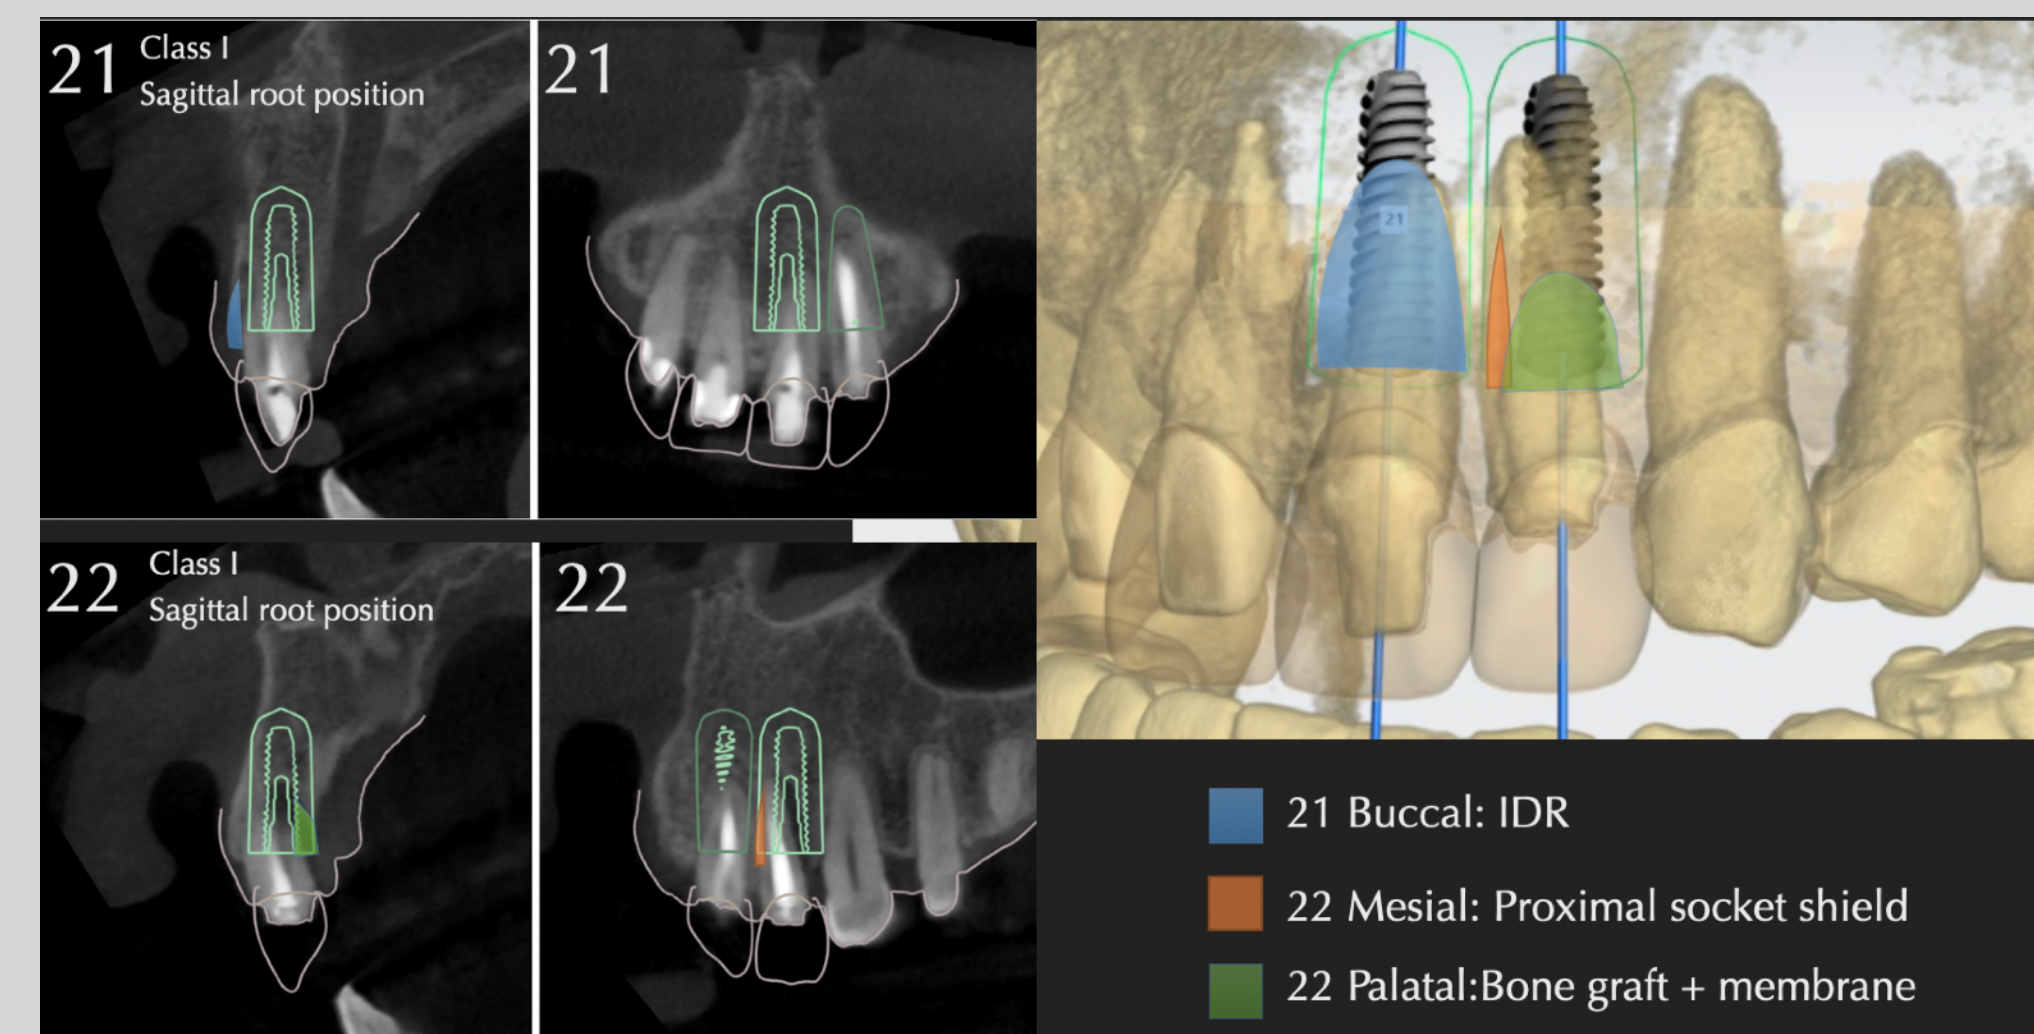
CBCT evaluation of implant angulation and positioning, demonstrating IDR, grafting, and root shield areas.
